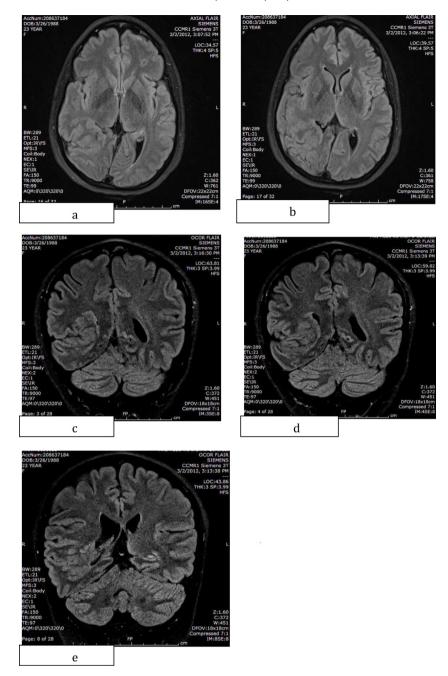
3 T MRI demonstrating gray—white disorganization, clozed-lip schizencephaly, and heterotopic gray matter. (a and b) Axial flair images; (c-e) coronal flair images.
